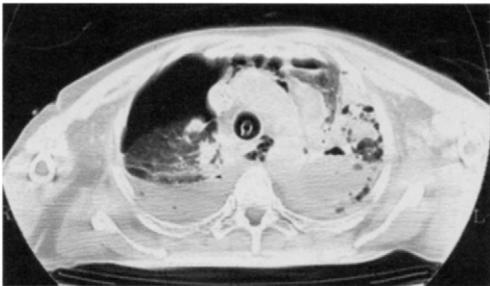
Axial CT. Bilateral pleural effusions, with right-sided major pneumothorax, non-homogenous infiltration of the left lung with atelectatic component and minor pneumothorax.
